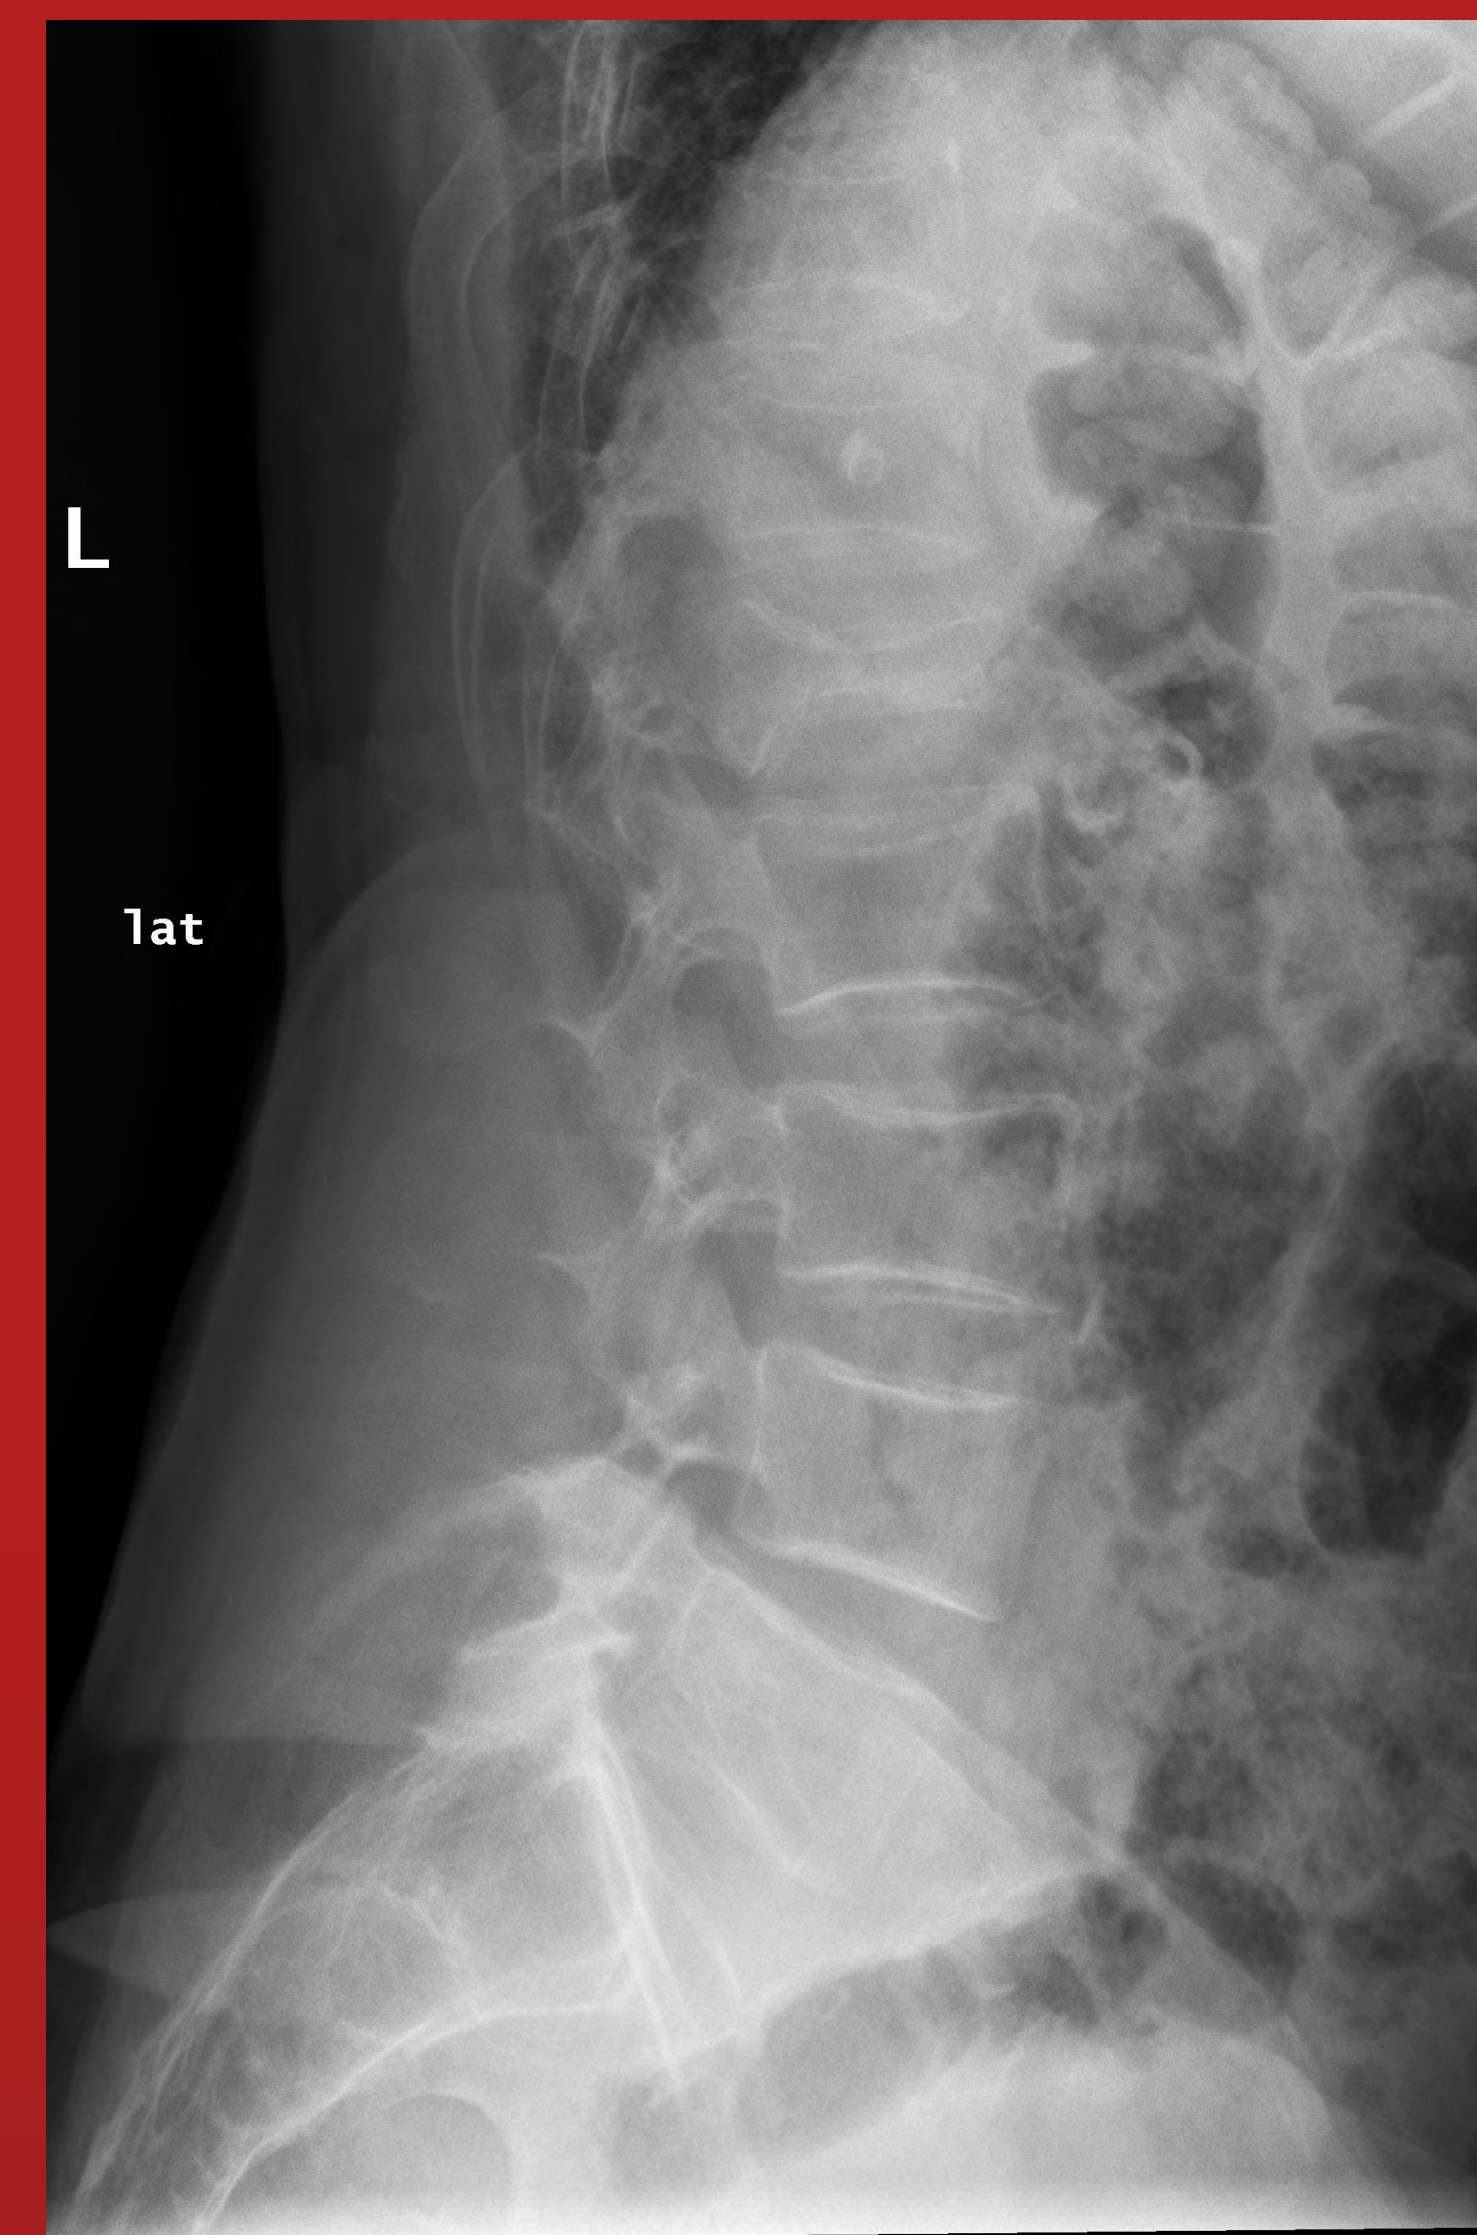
Lateral radiographic projection of lumbar spine demonstrating a compression fracture at L1. Significant loss of vertebral height is shown. Retrieved from facility PACS system.
